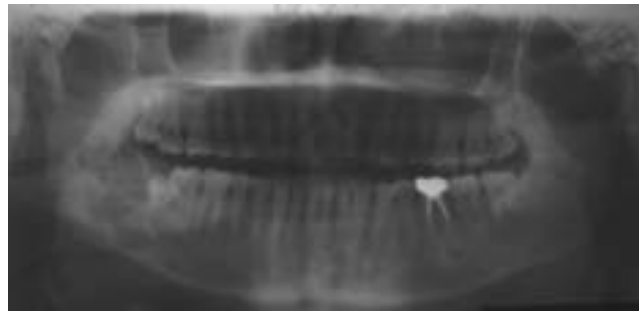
Mucoepidermoid carcinoma arising within a dentigerous cyst: panoramic radiograph shows a multiloculated radiolucency around impacted right mandibular third molar.
